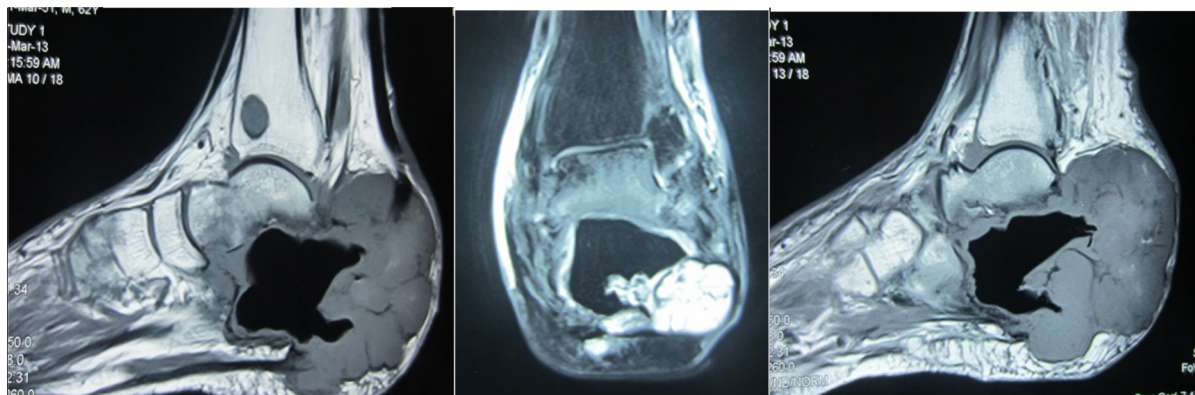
Selected MRI images delineating the mass arising from calcaneus and invading the surrounding soft tissue (hypointense on T1 and hyperintense on T2) with an associated metastatic lesion in the ipsilateral distal tibia.
